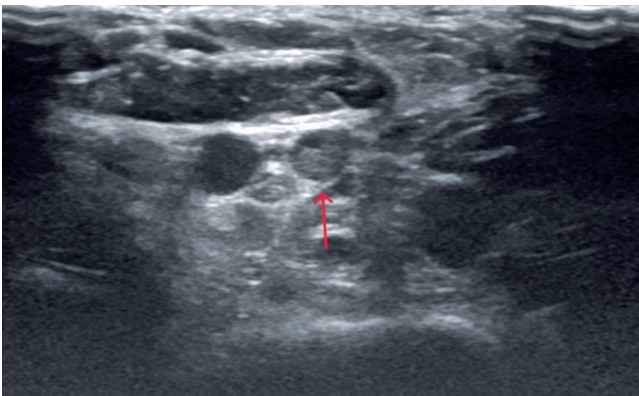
Follow-up axial gray-scale (B-mode) ultrasonographic image obtained during the second week. The medial plantar vein pair and the centrally located artery are visible. The left vein (red arrow) contains hyperechoic thrombus material with internal hypoechoic areas, suggestive of early recanalization and partial thrombus resolution.
